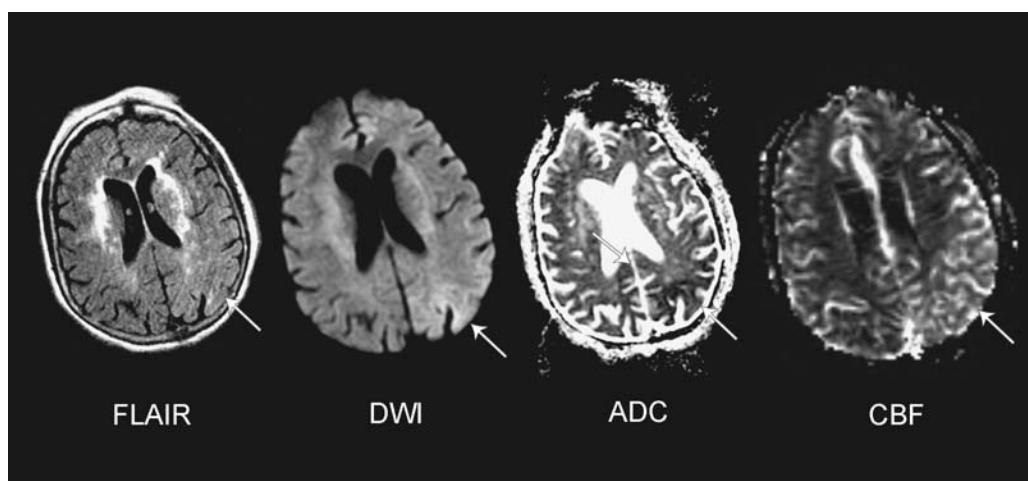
Eighty-five-year-old female with seizures. The FLAIR image demonstrates subtle hyperintensity in the left parietal lobe (*arrow*). The left parietal region is characterized by decreased diffusion with DWI hyperintensity and ADC hypointensity. In contradistinction to acute stroke, there is increased cerebral blood flow. Abbreviations: FLAIR, fluid-attenuated inversion recovery; DWI, diffusion-weighted images; ADC, apparent diffusion coefficient.
